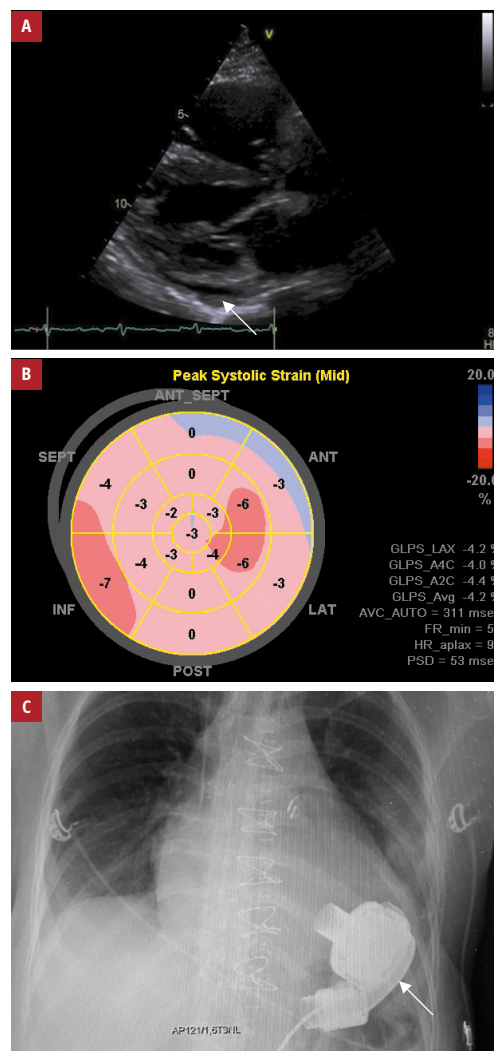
A – echocardiography, the parasternal view showing fluid in the pericardial sac (arrow); B – tissue Doppler echocardiography showing a reduced global longitudinal strain of the left ventricle; C – chest x-ray showing a left ventricular assist device (arrow)
